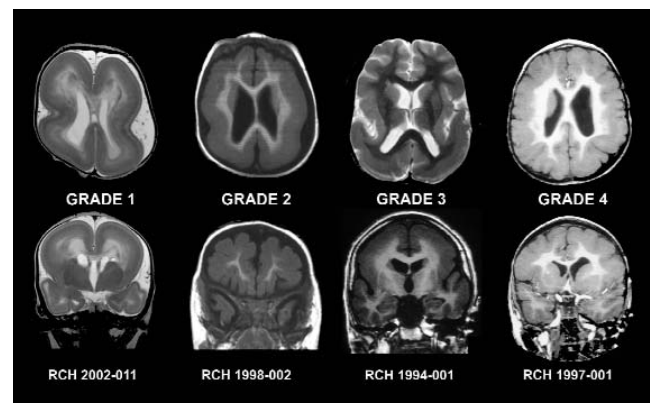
Imaging features of classical lissencephaly showing the four severity grades. All images are T1- or T2-weighted MRI scans. The top row shows axial scans and the bottom row coronal scans. Grade 1 is near complete agyria, grade 2 is posterior agyria and rudimentary shallow gyri anteriorly, grade 3 is posterior agyria and anterior pachygyria, and grade 4 is generalized pachygyria. MRI, magnetic resonance imaging
